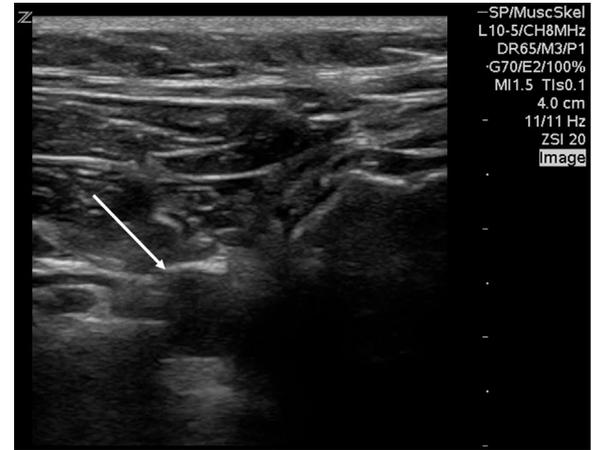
Point-of-care ultrasound of the right carotid artery of a patient with no palpable pulses, demonstrating a non-compressible pulsatile vessel (arrow).
